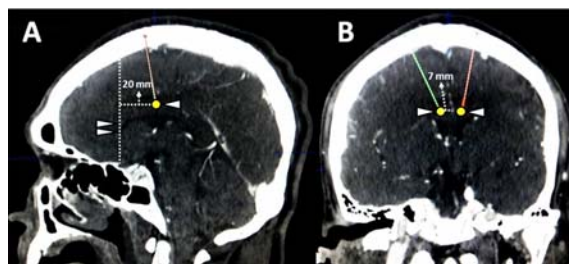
Localization of targets for anterior cingulotomy in navigation CT scan of the brain. (A) In sagittal CT, the targets at the anterior cingulate cortex (arrowhead) located 20 mm posterior to the anterior border of the lateral ventricle (double arrowheads); (B) In coronal CT, the targets situated at the anterior cingulate gyrus 7 mm lateral to the midline.
